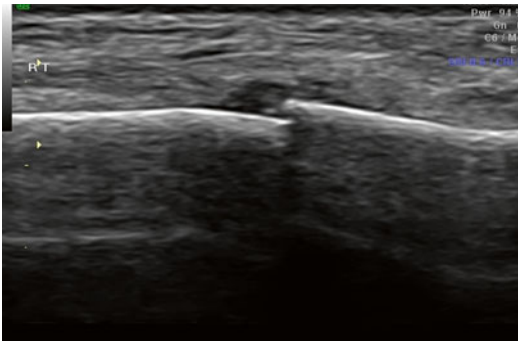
Shown in ultrasound exam a cortex irregularity and periosteal edema
